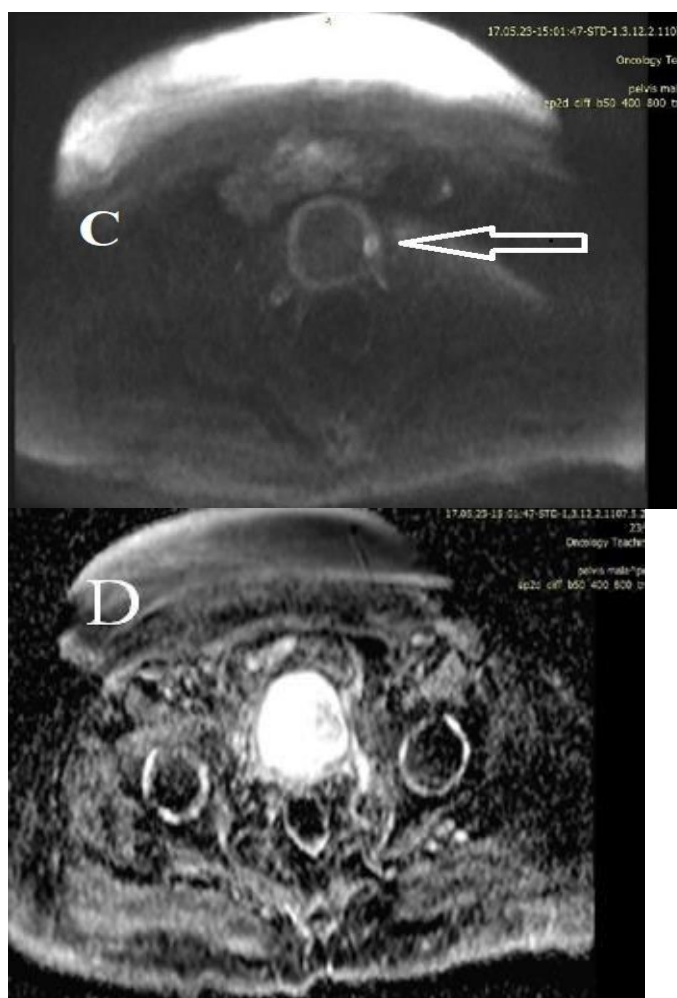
MRI of the pelvis for male patient 55 years old, presented with painless hematuria. (A&B): axial T1WI & T2 ,show that the tumor with intermediate SI seen in LT posterior lateral wall of the bladder. (C): axial DWI show that the tumor restricted in diffusion. (D): immediate sequence of DCE T1 axial fat suppression show that the moderately enhancing tumor in this case staging by DWI the tumor stage I bladder cancer and pathological report proved also that the tumor is stage I.
